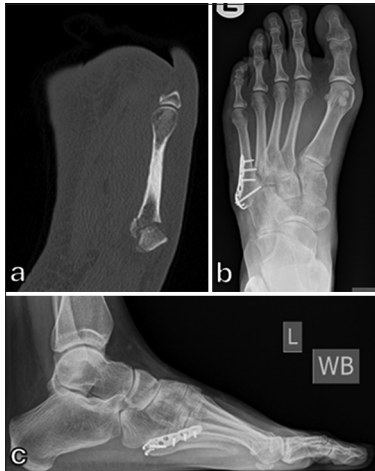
30-year-old female runner 8 weeks after injury. (a) Computed tomography scan showing comminuted tuberosity fracture. (b) Anteroposterior and (c) lateral radiographs following fixation with a hook plate.
